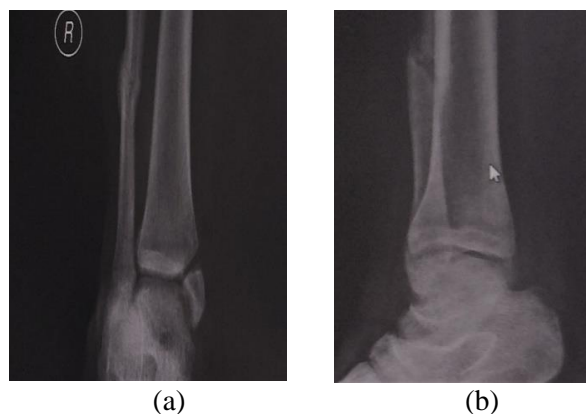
a- AP view of Pre- cast X-ray, b- Lateral view of Pre-cast X-ray. (Diagnostic AP and Lateral X-rays).
